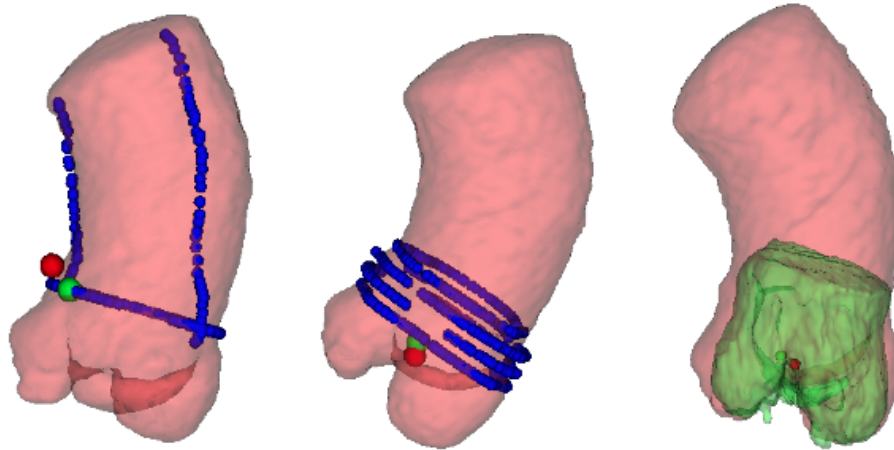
Registration results of the same patient from three different methods. Red surface - extracted from CT. Green surface - extracted from 3D TEE. Blue points - surface points manually extracted from US. Red point - Target identified on CT. Green point - Target identified on US. (a) XPlane image method. A smaller number of points and planes was used, but the larger field of view in the images allows more of the aortic root to be used during the registration. (b) Multiple plane method. Points are distributed more evenly in space, but cover a smaller volume and are derived from a lower resolution image. (c) Surface method. Provides large number of points distributed in 3D, but has low image resolution and image artifacts result. There is poor correspondence between the ultrasound and CT surface.
